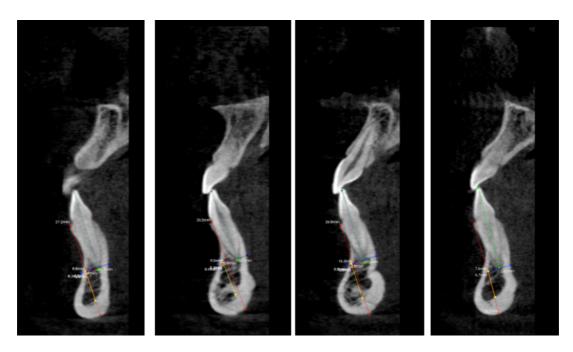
CBCT sagittal sections from patient 2. Incisors 32, 31, 41 and 42.
